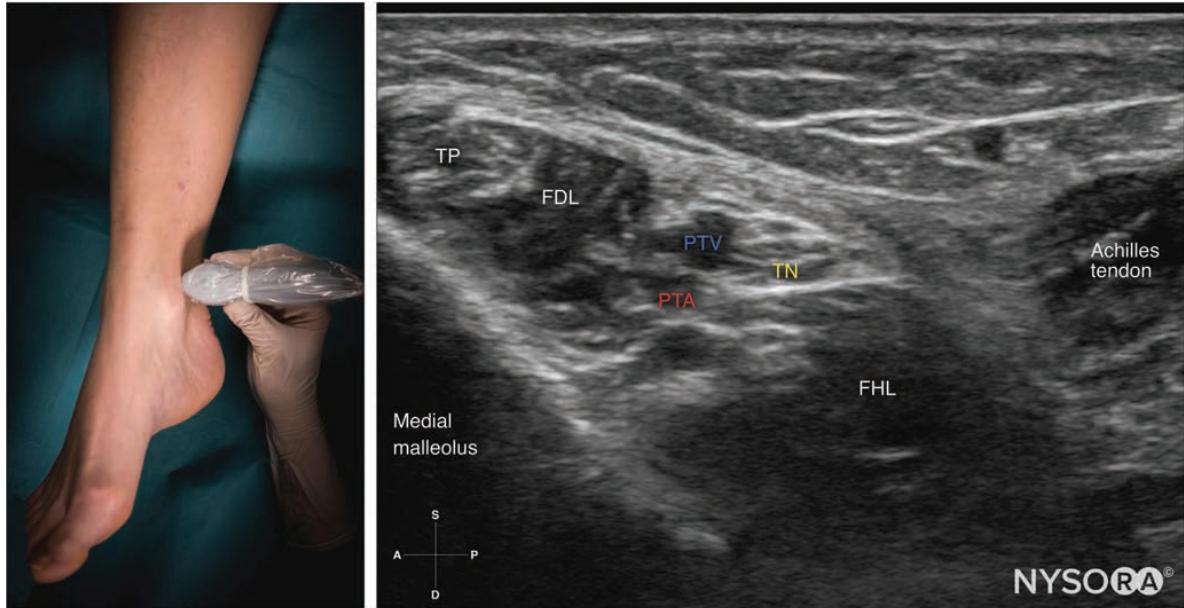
Transducer position and ultrasound anatomy to block the tibial nerve block. TP, tibialis posterior muscle; FDL, flexor digitorum longus; PTA, posterior tibial artery; PTV, posterior tibial vein; TN, tibial nerve; FHL, flexor hallucis longus.
